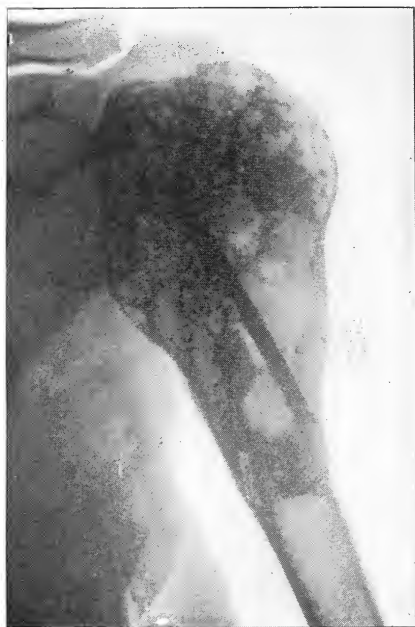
Hemorrhagic osteomyelitis upper end humerus. Female, age 20 years. X-ray after curettage and graft insert by H. L. Taylor.
